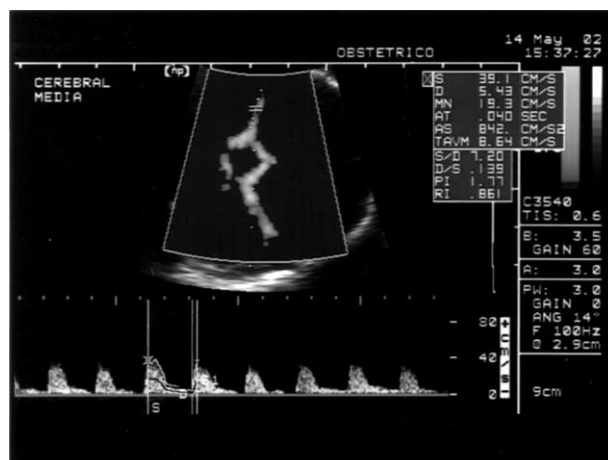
Doppler velocimetry in the middle cerebral artery showing the wall filter, insonation angle, site of insonation and measurement of peak systolic velocity (S), end-diastolic velocity (D) and resistance index (RI).
